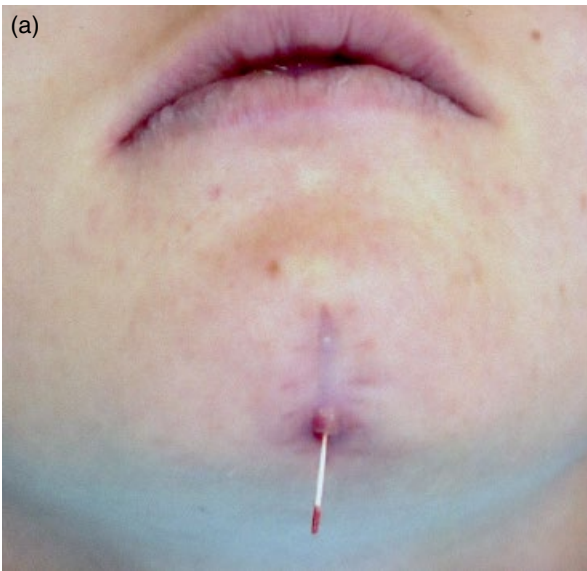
(a) The patient with that has epilepsy (grand mal) had been treated by multiple physicians for a “chin cyst”, which led to the scar tissue on the chin as well as a localized paresthesia. Eventually she was seen by an endodontist that traced the sinus tract with gutta-percha point. (b) The point traced to lower left central incisor. The pulp did not respond to sensibly tests and there was a periapical lesion evident on the radiograph. After first appointment where the canal was debrided and Ca(OH)_2 the sinus tract closed and was still closed at two-year re-evaluation. (Courtesy of Dr Buttke.)
